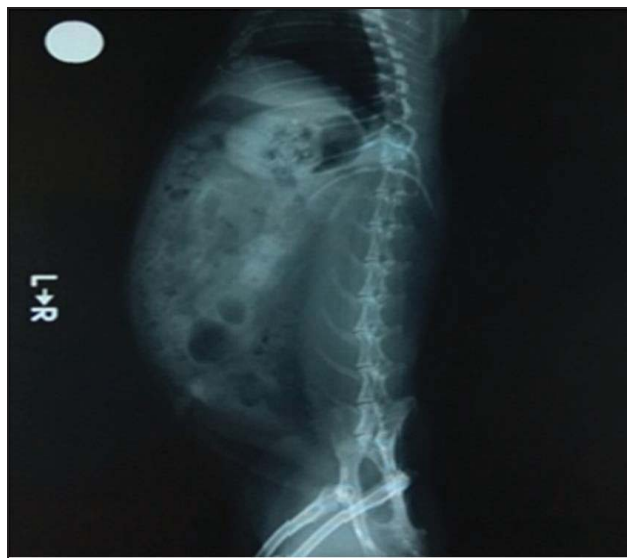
X-ray imaging radiograph at 0 hours
